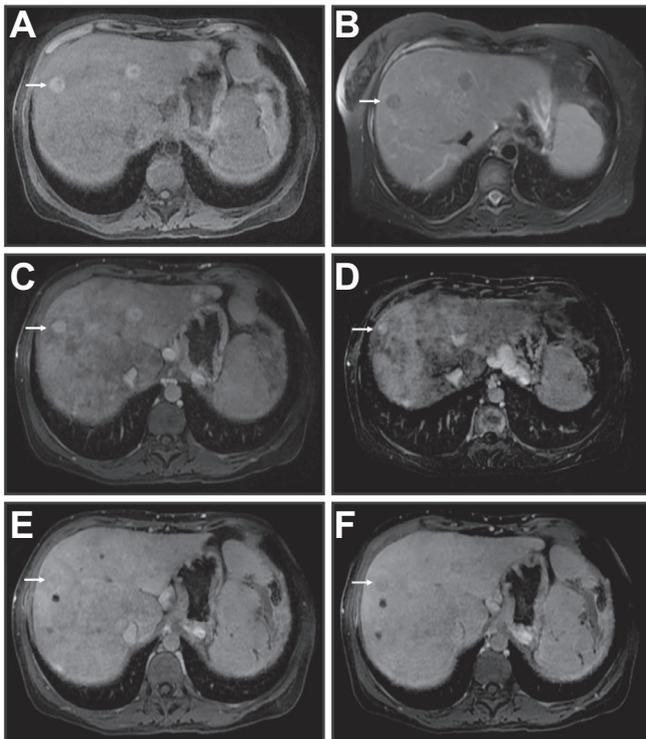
Multiple benign lesions with washout appearance in a 38-year-old woman with primary Budd-Chiari syndrome due to myeloproliferative neoplasm. The lesions appeared hyperintense on (A) precontrast T1-w images and hypointense on (B) T2-weighted images. (C-F) Extracellular gadolinium-based enhanced fat-suppressed T1-weighted GE MR images showed a 13 mm lesion in the right liver with arterial phase hyperenhancement (C), confirmed by image subtraction (D), mild signal hypointensity on portal venous phase (E) and signal hypointensity on delayed phase (F). Serum alpha-fetoprotein was 4 ng/L. The patient was followed up for 57 months and remained hepatocellular carcinoma-free.
